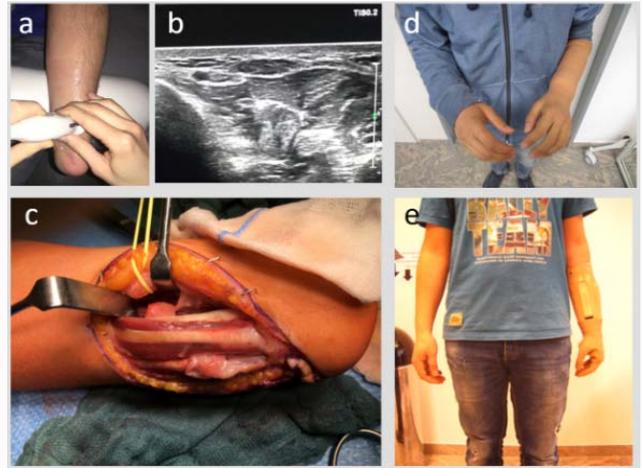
Patient 3, TR Amputee NRS 7; the algorithm revealed a painful neuroma of the ulnar nerve which could be visualized by ultrasound and measured a diameter of 37 mm (a,b); SNT of the ulnar nerve to nervus interosseus anterior (branch to pronator quadrates muscle) reduced allodynia at the residual limb to NRS 0.5 (c); patient could then tolerate socket and was fitted to two channel myoprosthesis and Silicone cosmesis (d,e).
